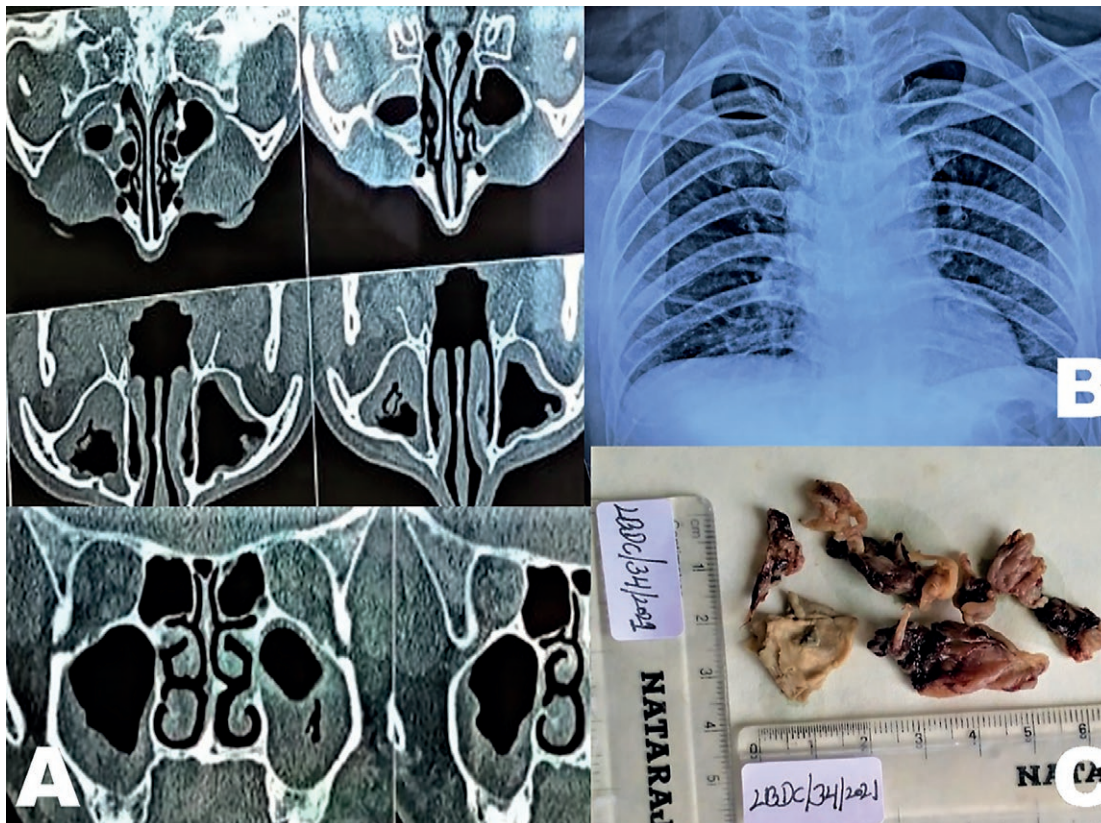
A) CT scan of paranasal sinus showing soft tissue density mass in maxillary sinus; B) Chest radiograph showing perihilar opacity along with non-homogenous infiltrates in all zones of both lung fields; C) Photograph of gross incisional biopsy mass.
